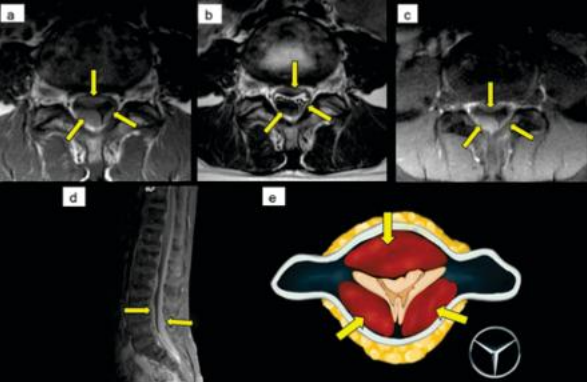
(A) Axial T1-weighted and (B) Axial T2-weighted images show loculated subdural collections (yellow arrows) that appear hyperintense on T1-weighted and hypointense on T2-weighted images. These collections are seen along the ventral, right dorsal, and left dorsal aspects of the thecal sac, resulting in compression of the neural elements. The axial distribution forms the characteristic "inverted Mercedes-Benz sign."
